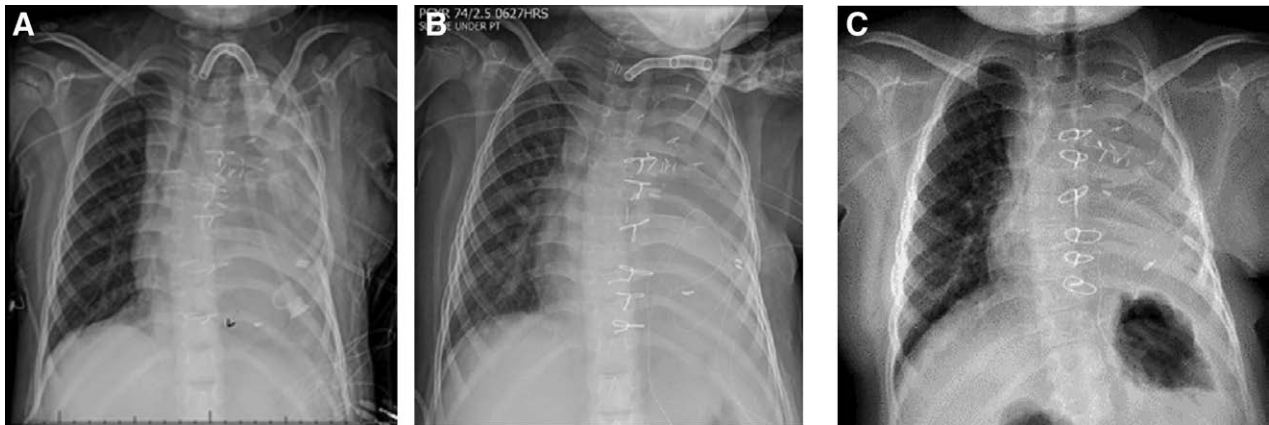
A: Preoperative CXR shows left lung collapse and pneumonia upon admission. B: Postoperative CXR postpneumonectomy. C: Postoperative CXR post OHT. CXR, chest x-ray; OHT, orthotopic heart transplantation.
